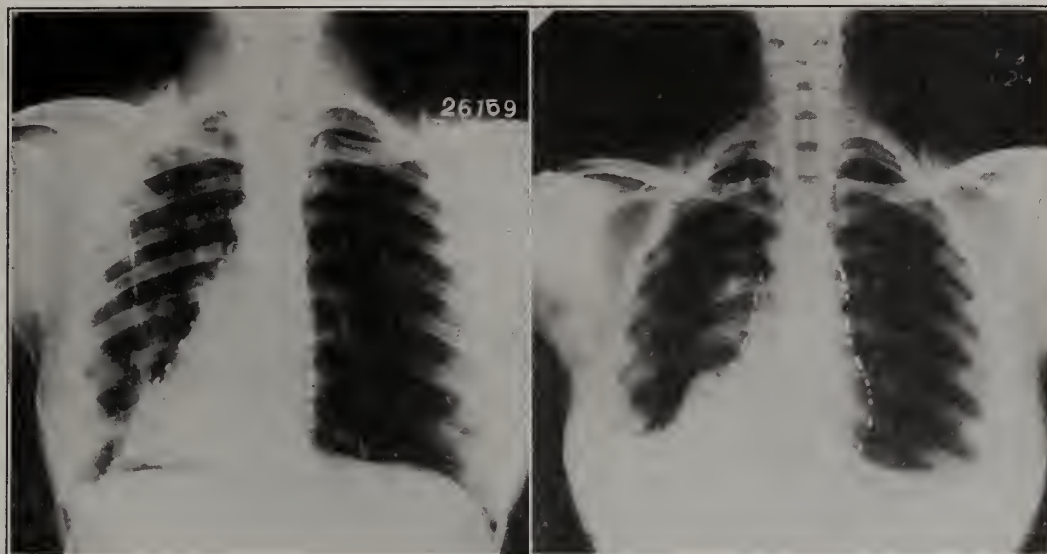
Roentgenograms of chest of F. B. The one on the left shows the condition of the left lung and heart following the induction of a partial pneumothorax. Adhesions between the pericardium, the lung and the diaphragm interfere with proper compression of the lung and keep the heart displaced to the left. The roentgenogram on the right was taken after paralysis of the diaphragm and before any more air was introduced.
